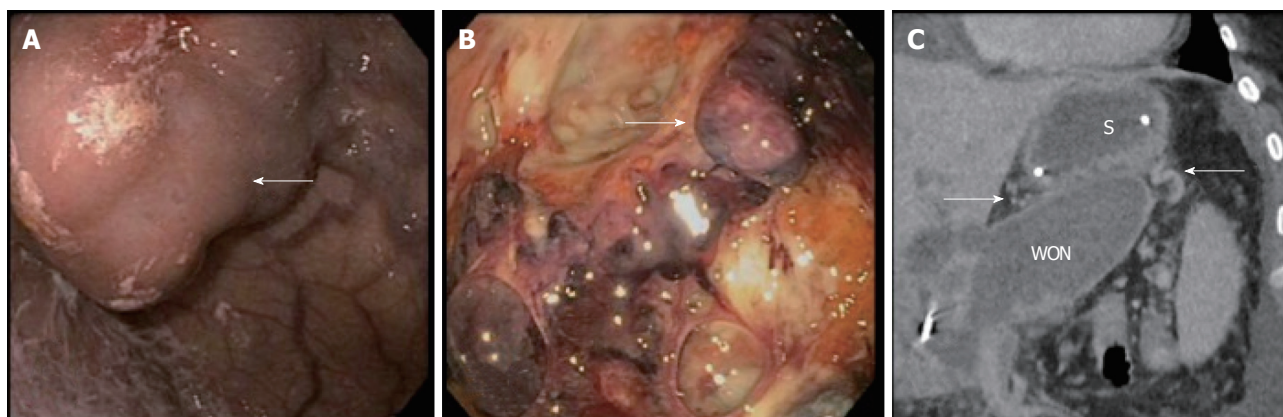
Varices identified through various methods. A: Large gastric varix (arrow) seen endoscopically; B: Peri-gastric varix (arrow) seen within the cyst cavity during endoscopic necrosectomy; C: Computed tomography scan showing gastric varices (arrows) in close proximity to the stomach (S) and walled off necrosis (WON).
